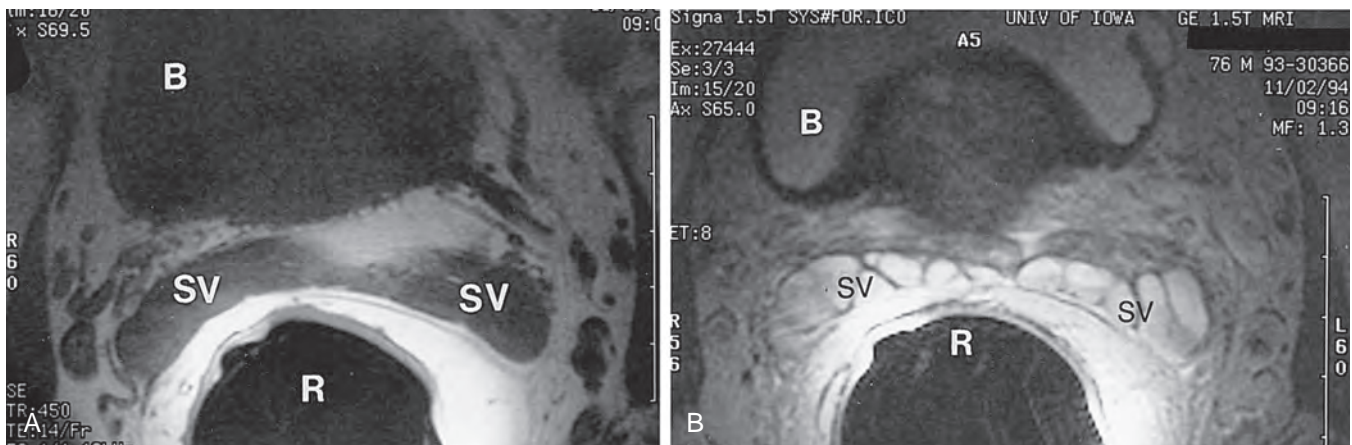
Transaxial magnetic resonance imaging of normal seminal vesicles (SV) with endorectal coli. A, T1-weighted image. B, T2-weighted image. B, bladder; R, rectum.
